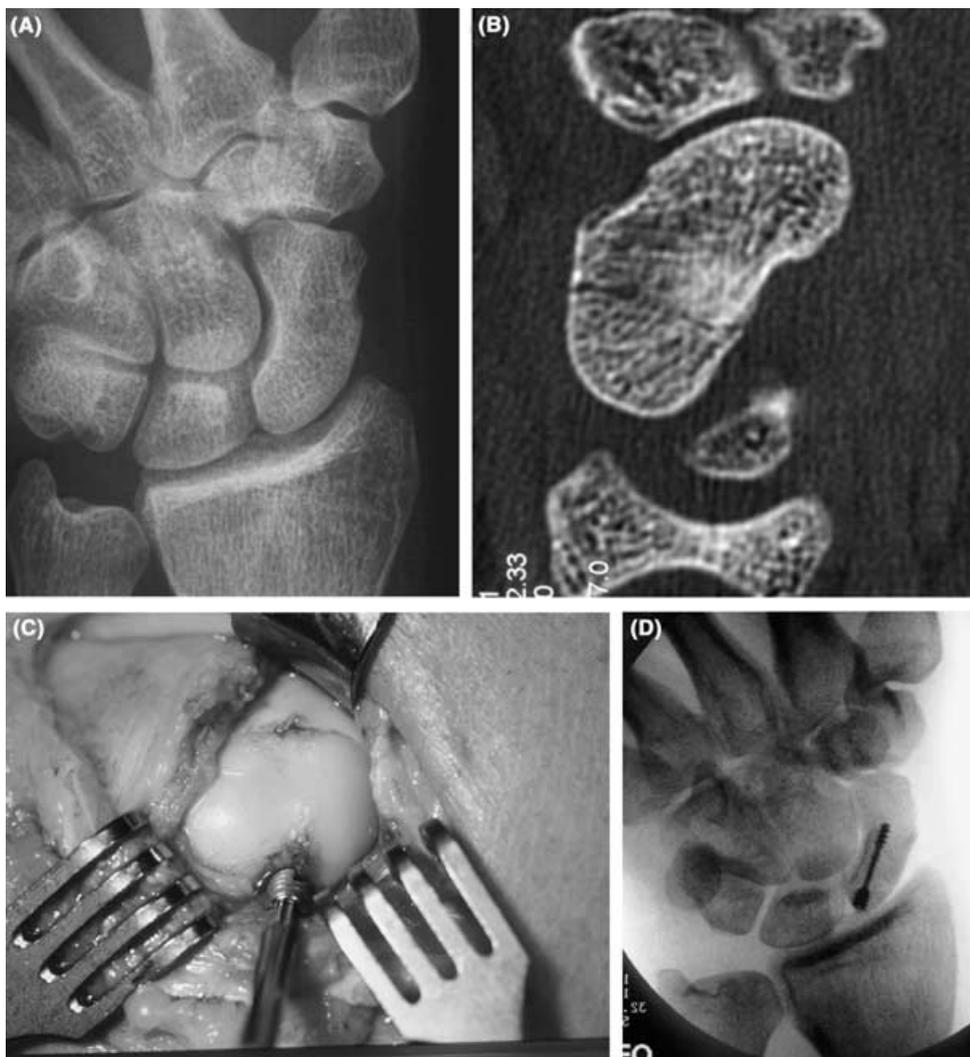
(A) Suspected fracture of the scaphoid. (B) Proximal pole fracture detected on CT scan. (C) Intraoperative view of the dorsal approach with a mini Herbert screw inserted through the proximal pole. (D) Posteroanterior view demonstrating the screw buried beneath the cartilage.
